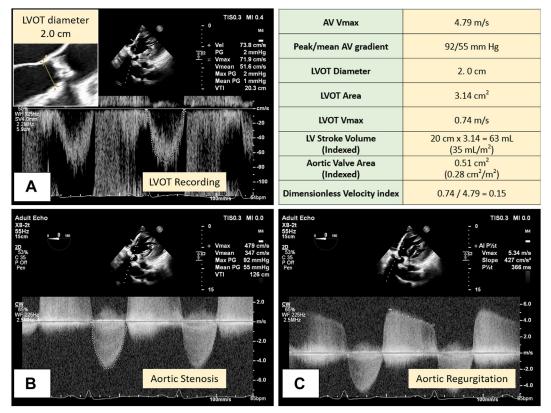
Hemodynamic parameters for evaluation of valvular AS severity in case 1. Spectral Doppler tracings by TEE were obtained from the 5-chamber transgastric view (A, B, and C), and the LVOT diameter (*inset to panel A*) was obtained from the midesophageal long-axis view. Panel A represents LVOT and panels B and C represent AV recordings of AS and regurgitation, respectively. Data analysis is summarized in the table located in the *top right panel*. *LV*, Left ventricle, *Vmax*, maximum velocity.
